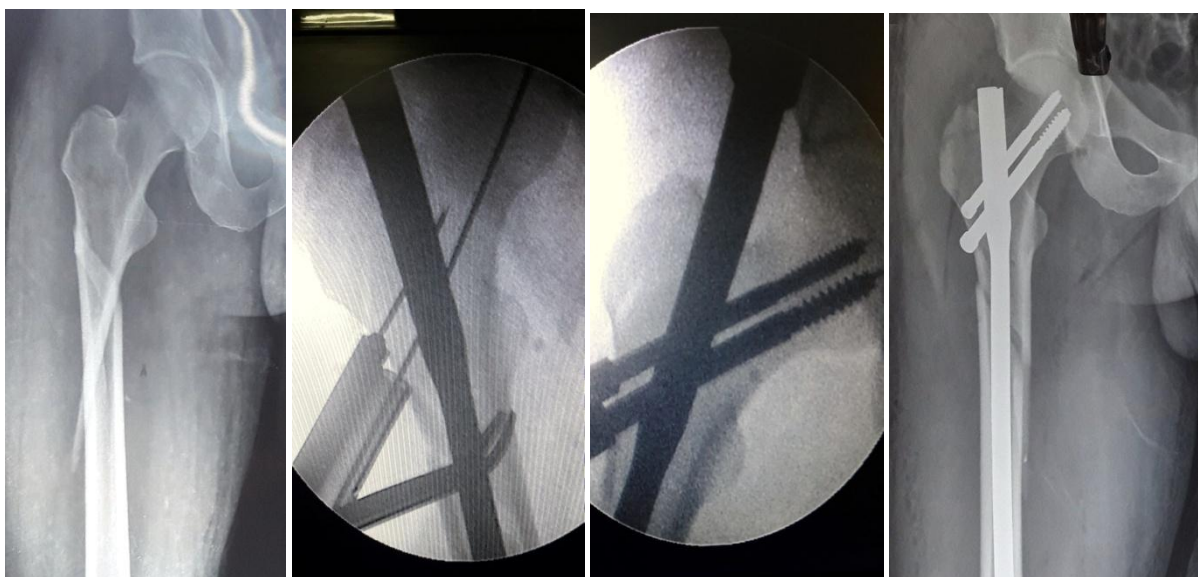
Preoperative, Intraoperative and postoperative x-rays of patient showing no varus deformity.
